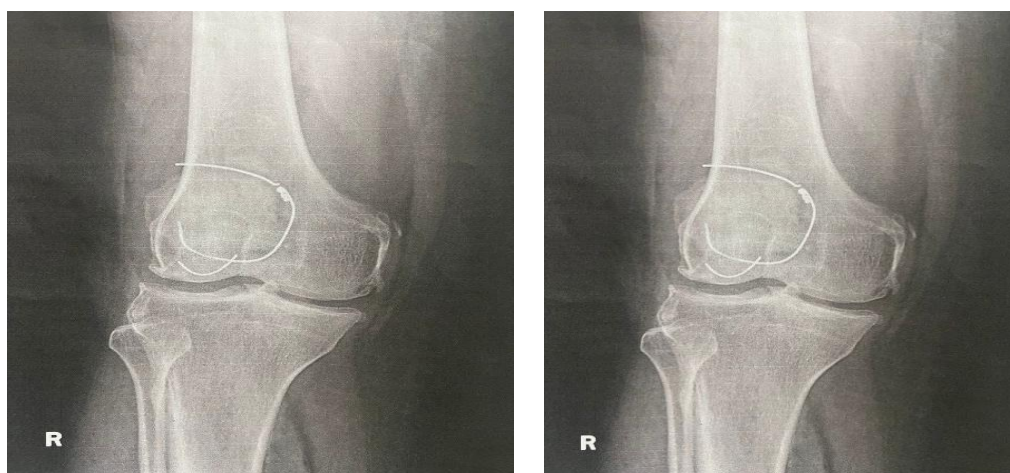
Radiograph of right knee showing the broken patella cerclage wire with a migrated fragment posteromedially.
